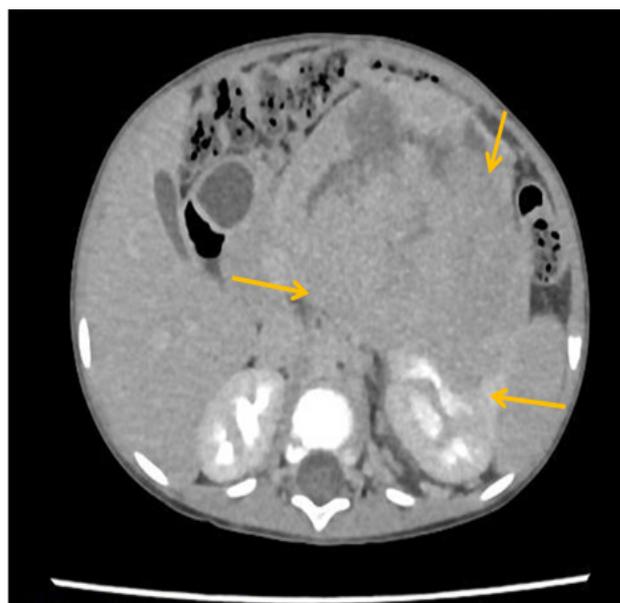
MRI of the abdomen reveals a large, heterogeneously enhancing mass measuring 9 × 7 × 8 cm arising from the left kidney. The mass contains necrotic areas and extends across the midline.
